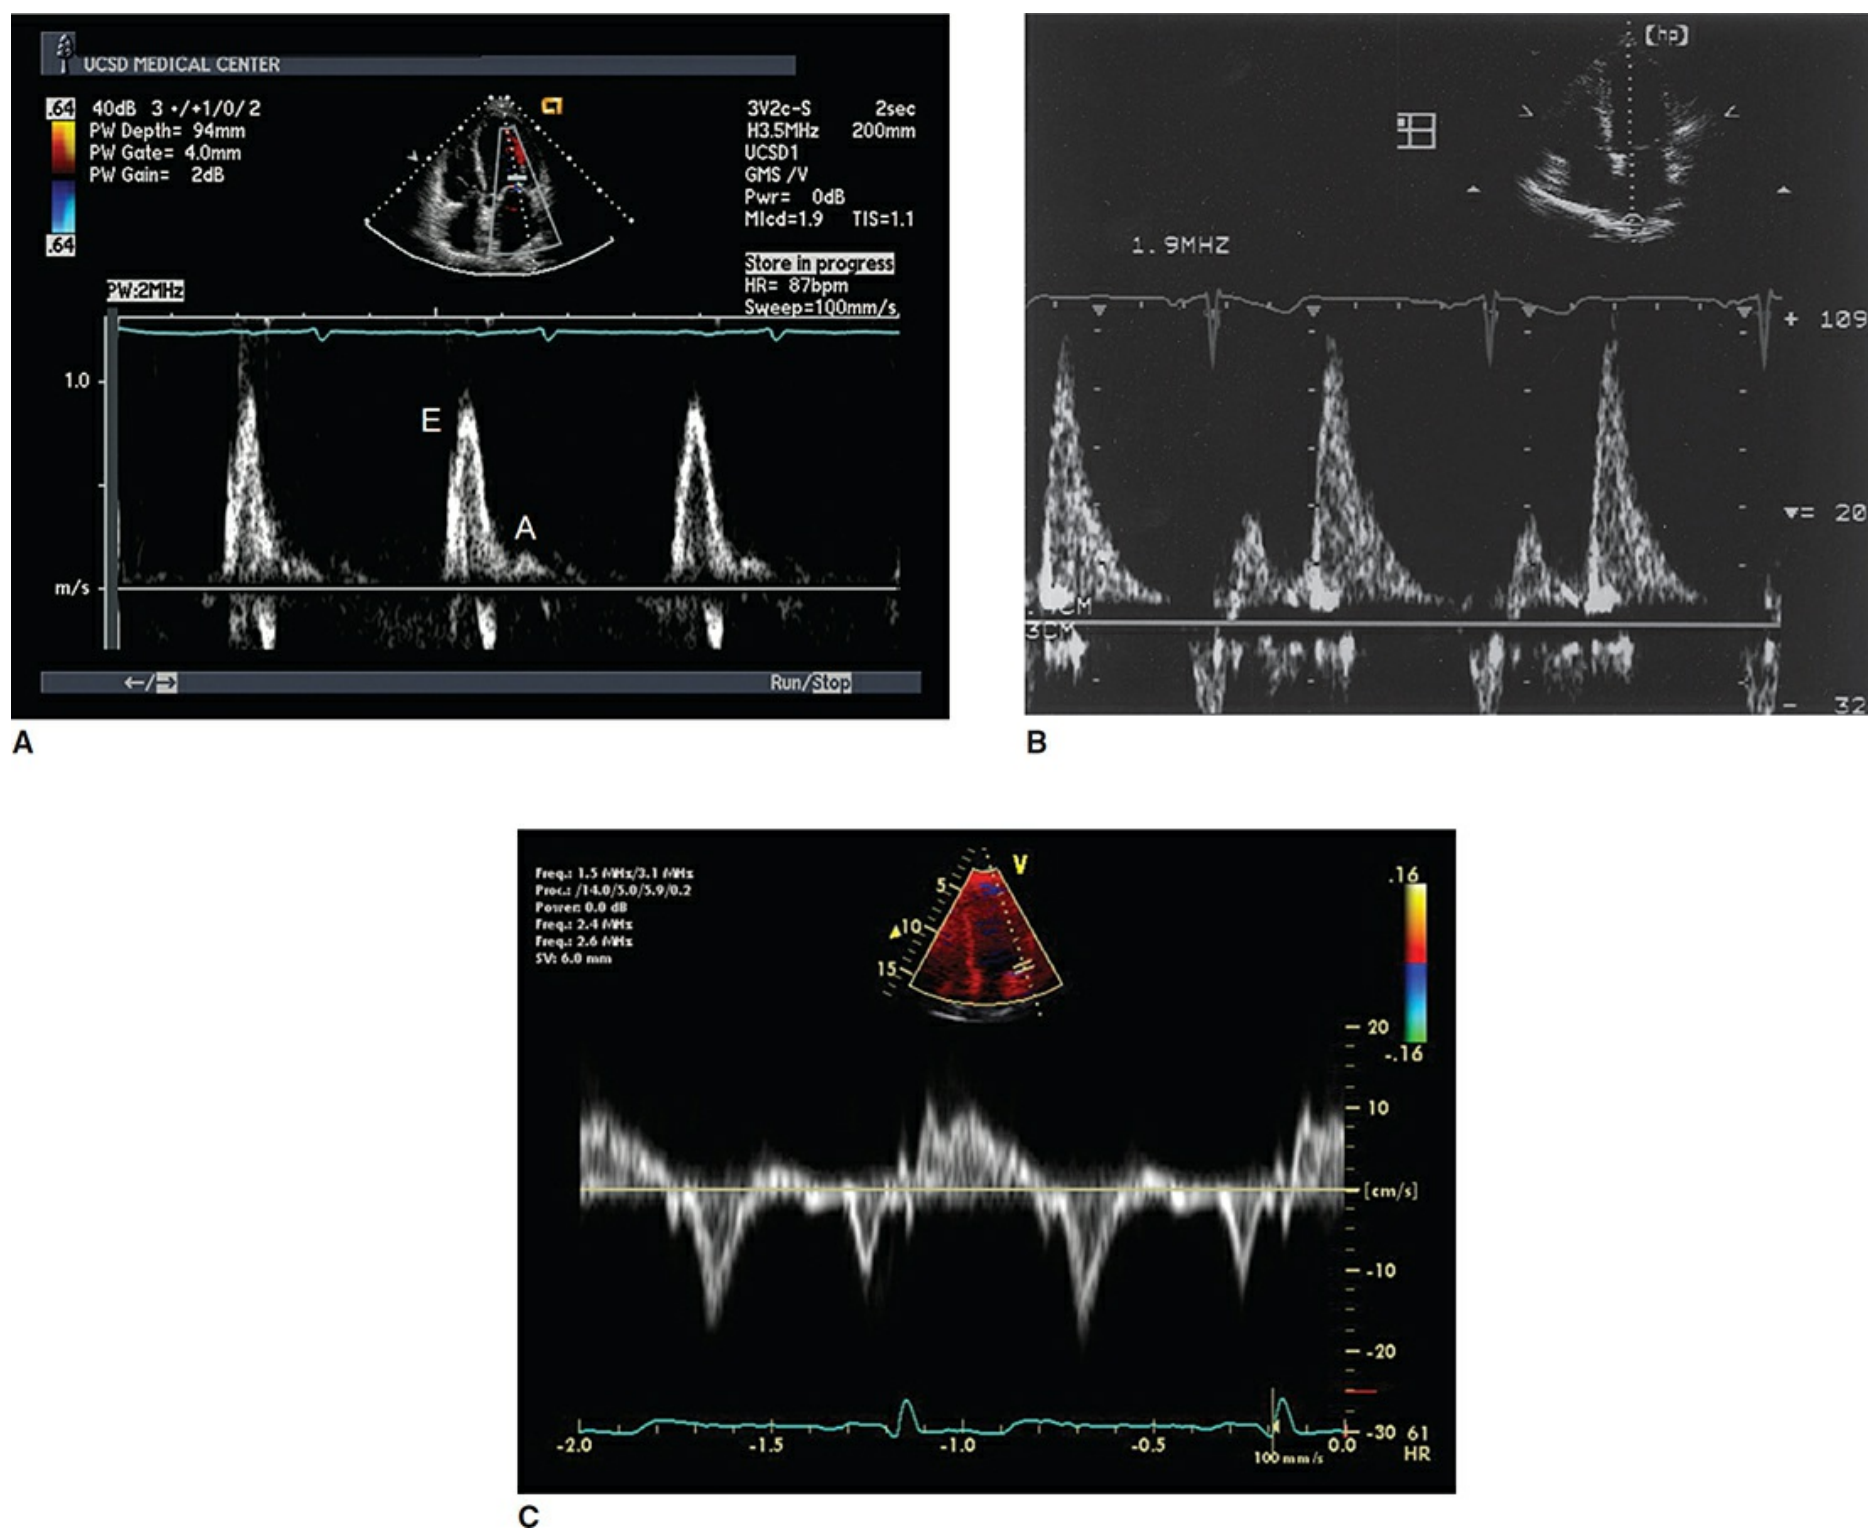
(A) Pulsed-wave Doppler (PWD) tracing. (B) PWD recording of pulmonary venous flow. The S wave is small, whereas the D wave is prominent. (C) Tissue Doppler recording of lateral mitral annular motion (apical transducer position). Peak early diastolic annular velocity is 17 cm/s.
